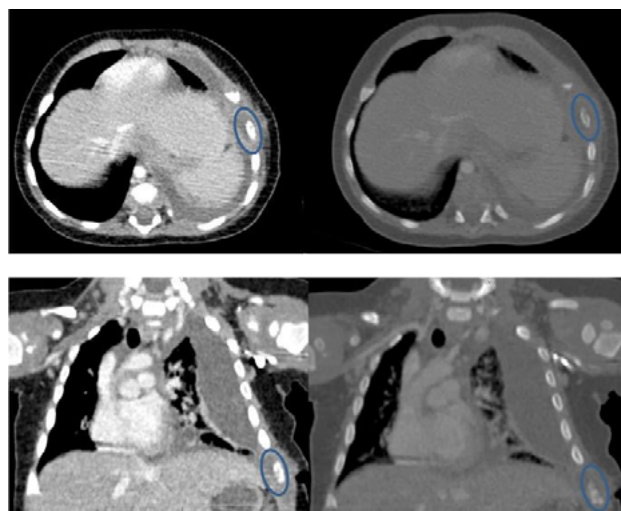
CT images: (a) axial Mediastinal window shows an abscess englobing the middle arch of the 7th left rib and in (b) axiale Bone window image showing cortical erosions of the same left rib (circle).CT frontal view (c and d) showing a left pleural loculated effusion.
